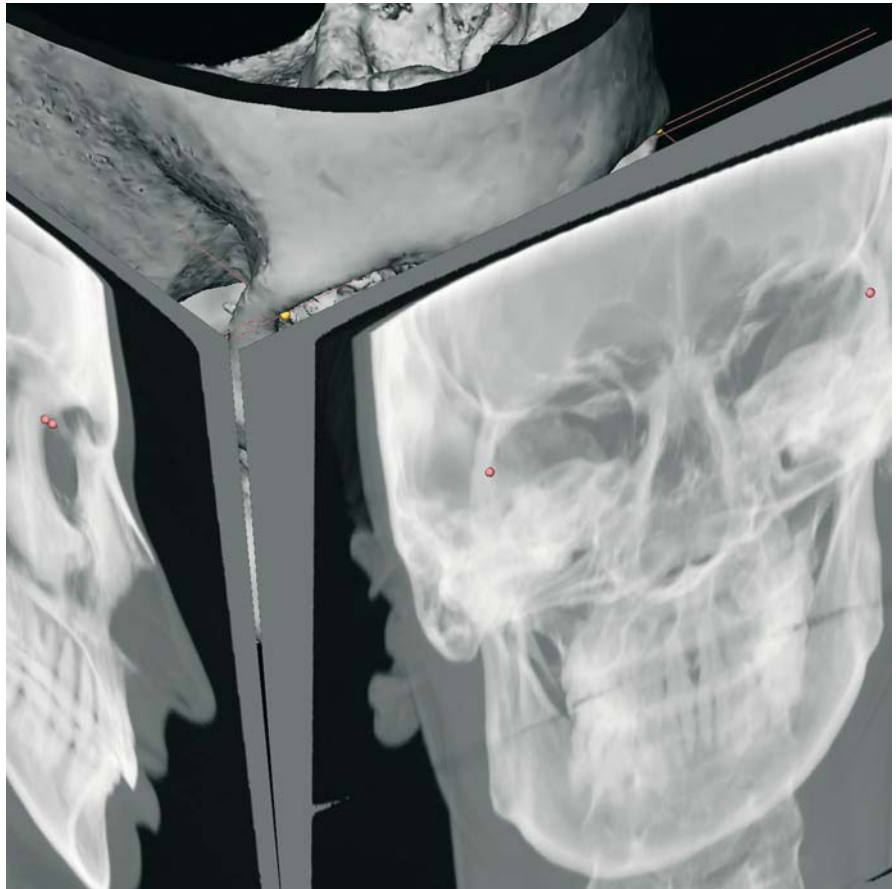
Frontozygomatic_r and Frontozygomatic_l. Frontal view (3-D CT, patient K.C.)
